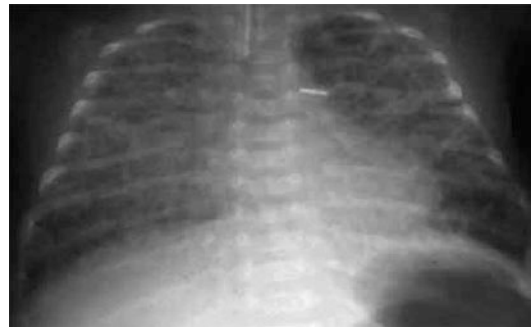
Classic bronchopulmonary dysplasia. Anteroposterior chest X-ray shows interstitial images, with diffuse cystic shadows in a 50-day-old child, a 34-week premature newborn whose weight at birth was 1980 g. Patient did not receive surfactant and underwent permeable ductus surgery
